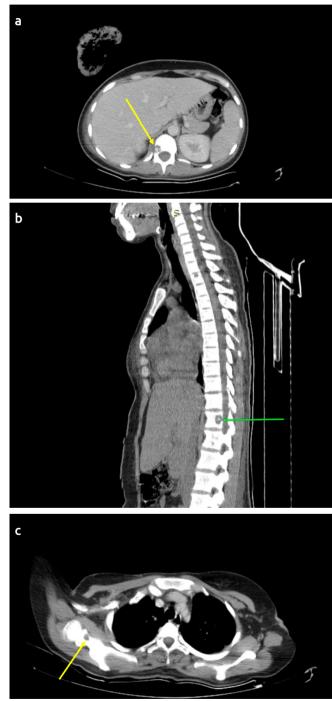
(a): Computed tomography scan axial section demonstrating an osseous metastasis in a thoracic vertebra, (b): Computed tomography scan sagittal section demonstrating an osseous metastasis in a thoracic vertebra, (c): Computed tomography scan sagittal section demonstrating an osseous metastasis in the right scapula
